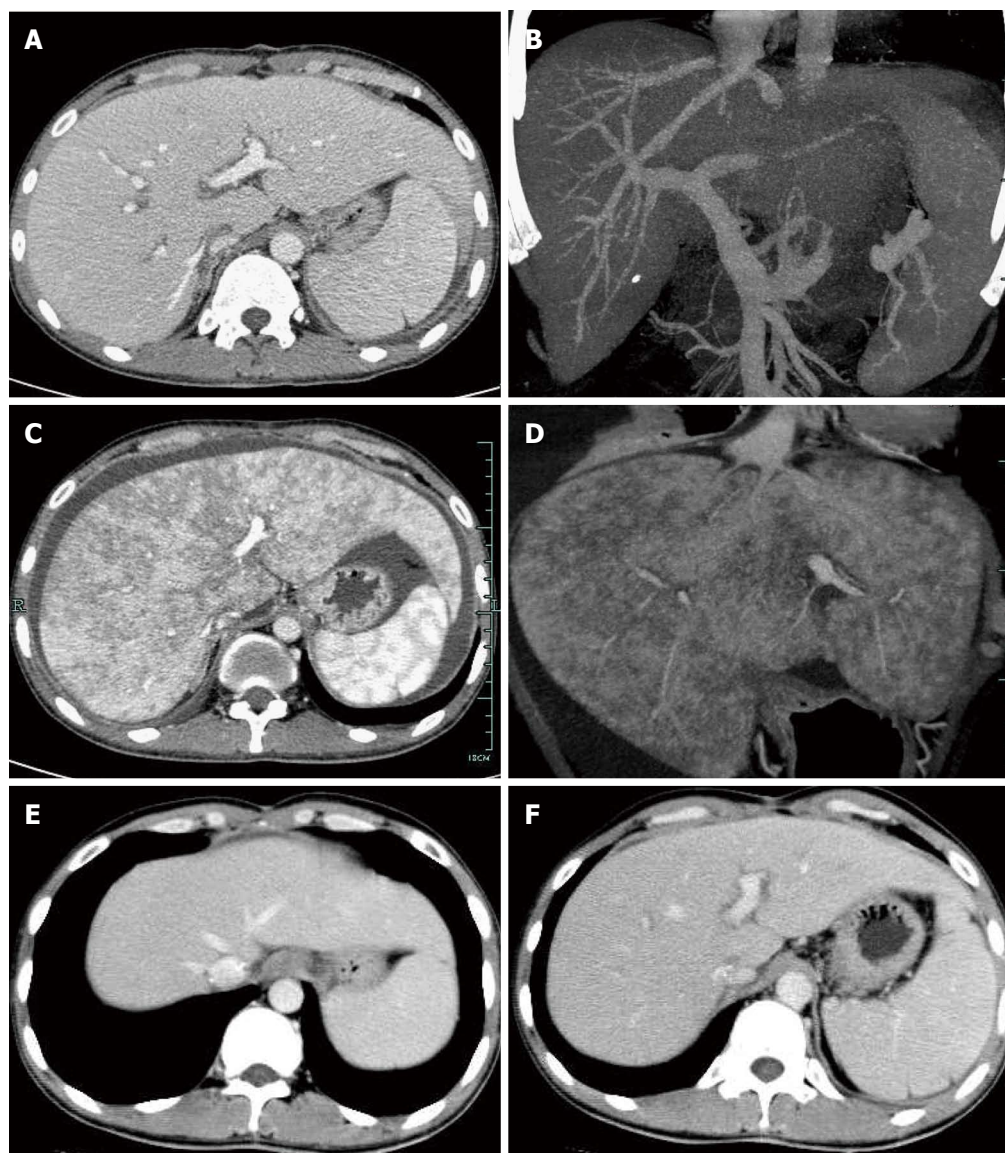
Computed tomography revealed excellent reconstructed blood flow in the hepatic veins, portal vein and hepatic artery at 14 d after transplantation (A, B), enlarged liver with patchy enhancement, obscure hepatic veins and massive ascites at 80 d (C, D), and normal radiologic presentations with resolved ascites and patchy enhancement, and recovered hepatic vein flow at 120 d (E, F).
